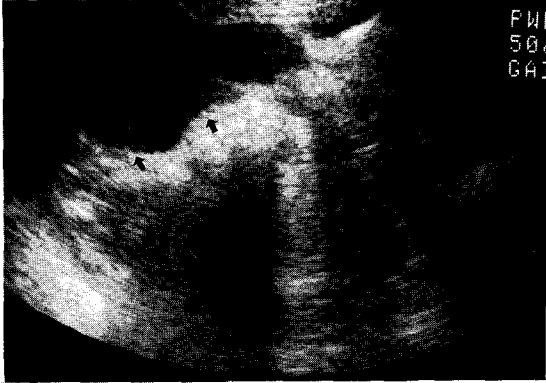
Ultrasonogram of 43-year-old man on 4 days after the laparoscopic cholecystectomy reveals a large amount of intraperitoneal free fluids in right paracolic gutter (arrows). There was also free fluids in subhepatic space and pelvic cavity (not shown). But these are non-specific findings of free fluids such as bile, hemorrhage, transudate or other exudate.
